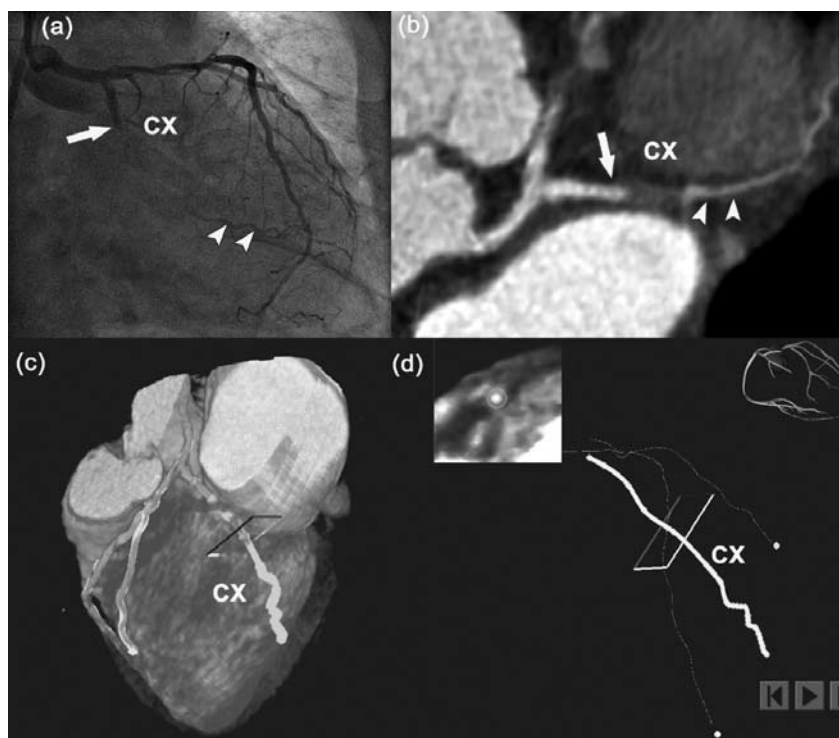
(a) Invasive coronary angiogram, showing a chronic total occlusion (arrow) of the circumflex artery (CX). Only the very distal part of the vessel is visible through collaterals (arrowheads) (b) Corresponding CT image (curved multiplanar reconstruction): compared to the angiographic information the occlusion appears much shorter and consists of non calcified tissue. (c) The CT dataset has been uploaded in the navigation software; the course of the CX, including the path of the occlusion, is marked by a green line overlay. (d) The course of the CX has been marked as a yellow line. The rectangular which is present in panel c and d marks the location of the wire tip in the vessel. The inset in panel d represents the perpendicular cross-sectional view of the vessel to allow the steering of the guidewire in the desired direction.
